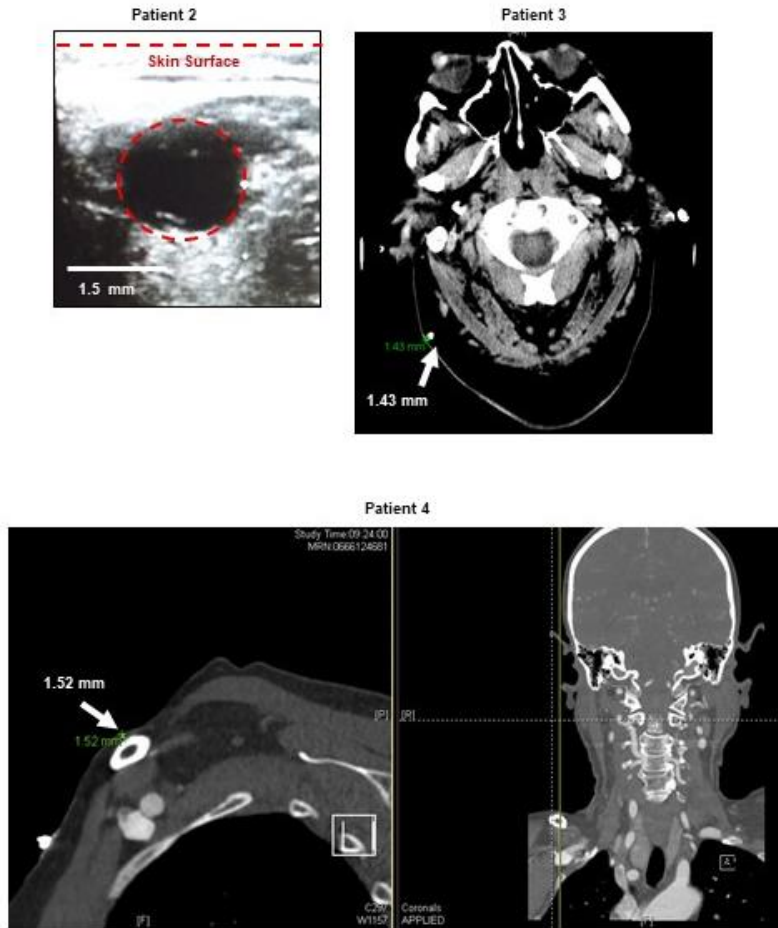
In vivo measurements of skin thickness made via radiographic and ultrasound imaging. Ultrasound (patient 2) and CT (patients 3,4) images of patients over the location of device mounting, with accompanying skin thickness measurements, with the red dashed line indicating the outline of the shunt. Software-based measurements are available on CT images on patients 3 and 4, whereas the catheter (OD = 1.5 mm) serves as the scale bar for the Ultrasound image. The green text in the image is the same as the larger, white text, and indicates measured skin thickness.
